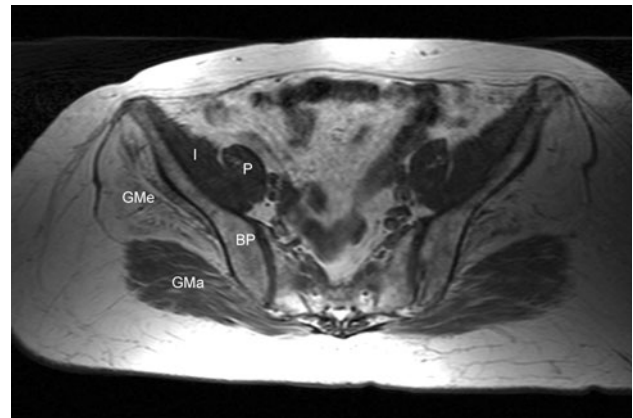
MRI scan T1 weighted of pelvis and hip, showing fatty degeneration of hip extensors (glutei muscles) preserving hip flexors (iliopsoas muscles) (pat. 6). *BP* bony pelvis, *I* iliacus muscle, *P* psoas muscle, *GMa* gluteus maximus muscle, *GMe* gluteus medius muscle
